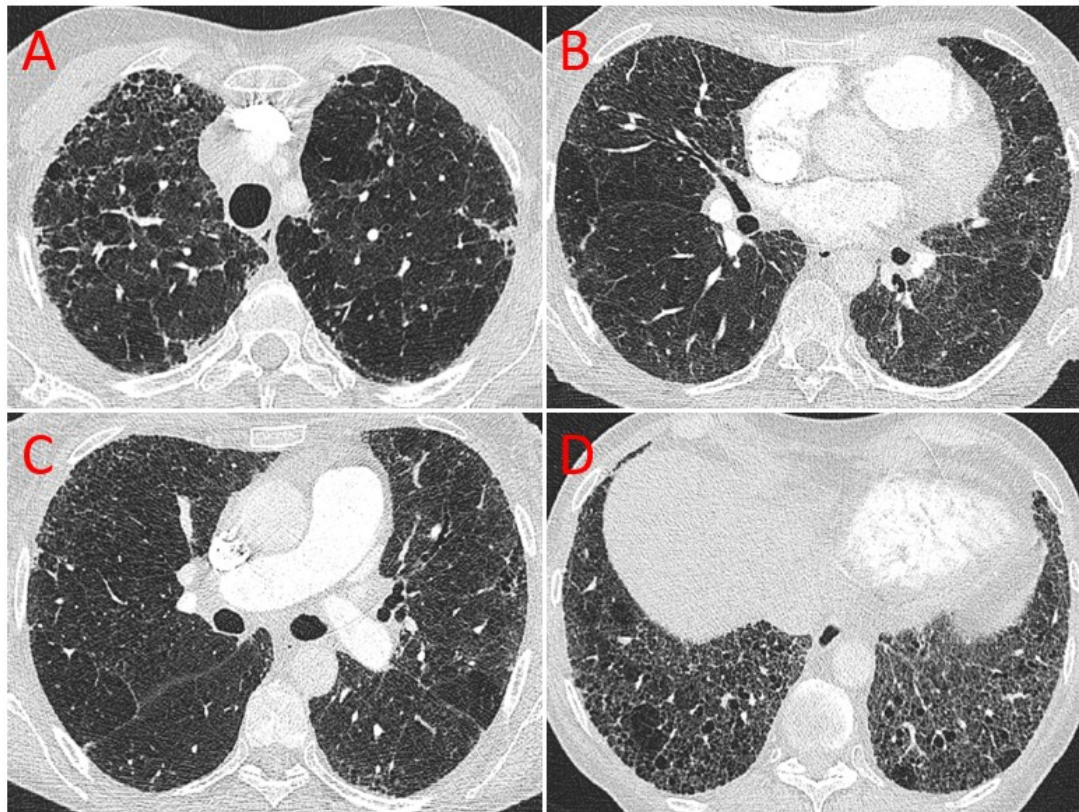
High resolution CT dicom's from a patient with an undifferentiated connective tissue disease associated ILD
